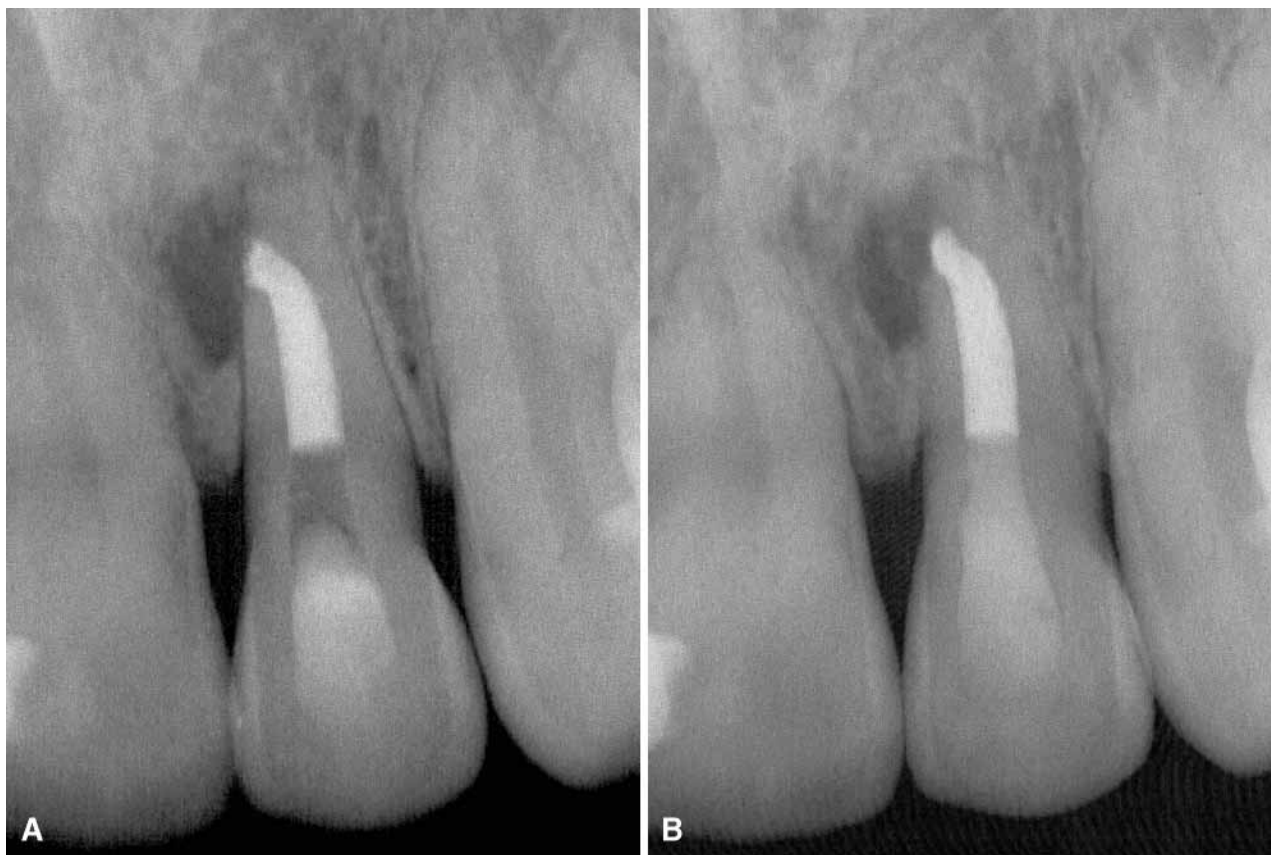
Persistent disease after endodontic treatment. A. Immediate post-operative radiograph of maxillary lateral incisor with apical periodontitis. B. Persistent disease at 1 year.
